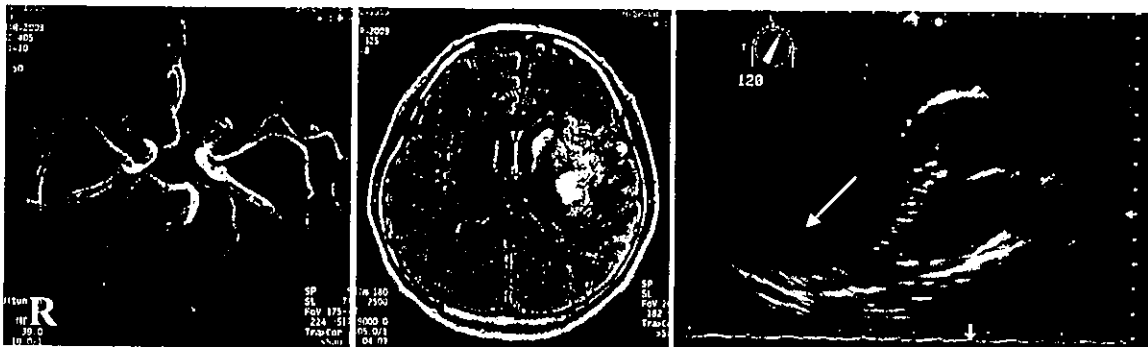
発症 6 日後の MRA, MRI および経食道心エコー所見
